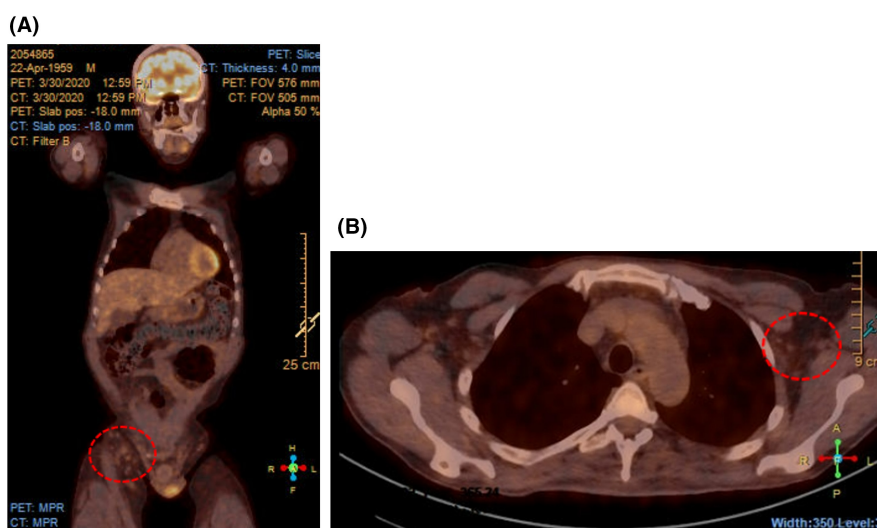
PET-CT performed after two cycles of B-BV therapy: (A) iliac region, (B) axillar region. B-BV, bendamustine plus brentuximab vedotin; PET-CT, positron emission tomography computed tomography.
